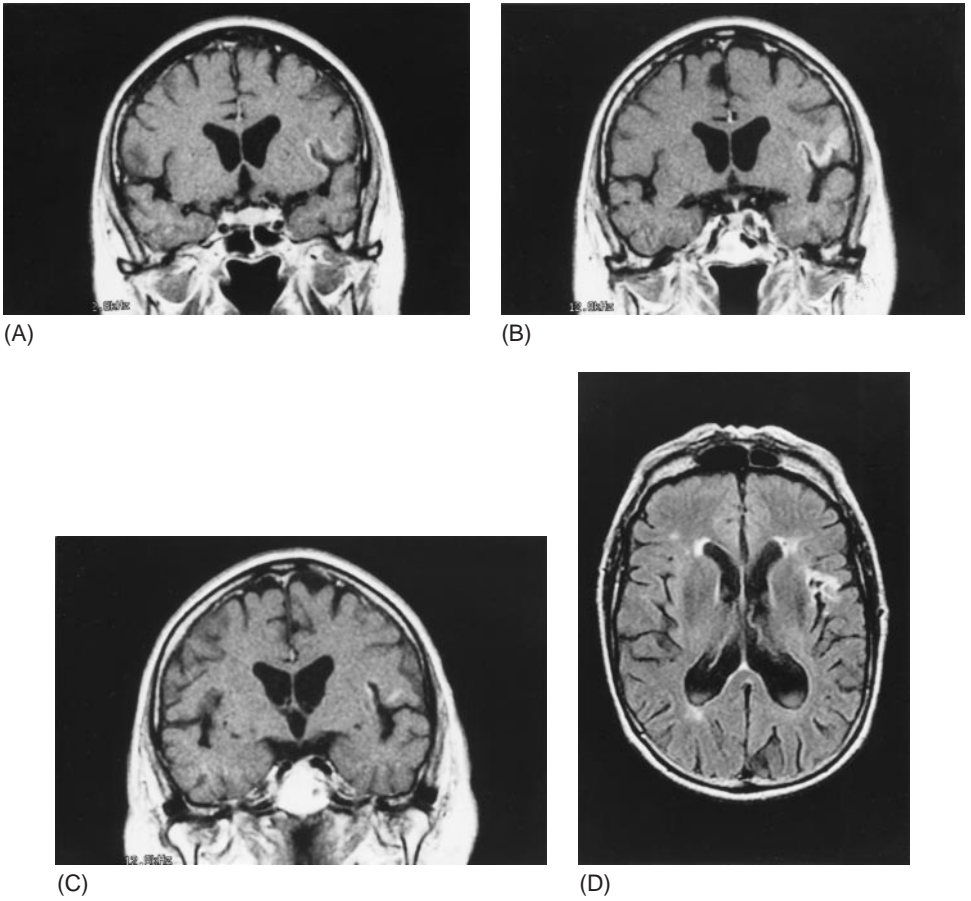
Coronal T1-weighted brain MRI slices after gadolinium (A–C) and axial FLAIR slice (D) disclose in the left cerebral hemisphere a focal anterior insulo-opercular lesion occupying the sulcus circularis insulae, the gyri breves insulae, the gyrus frontalis inferior, and the gyrus precentralis. Several small bilateral white matter lesions of presumed vascular origin are shown as well.
